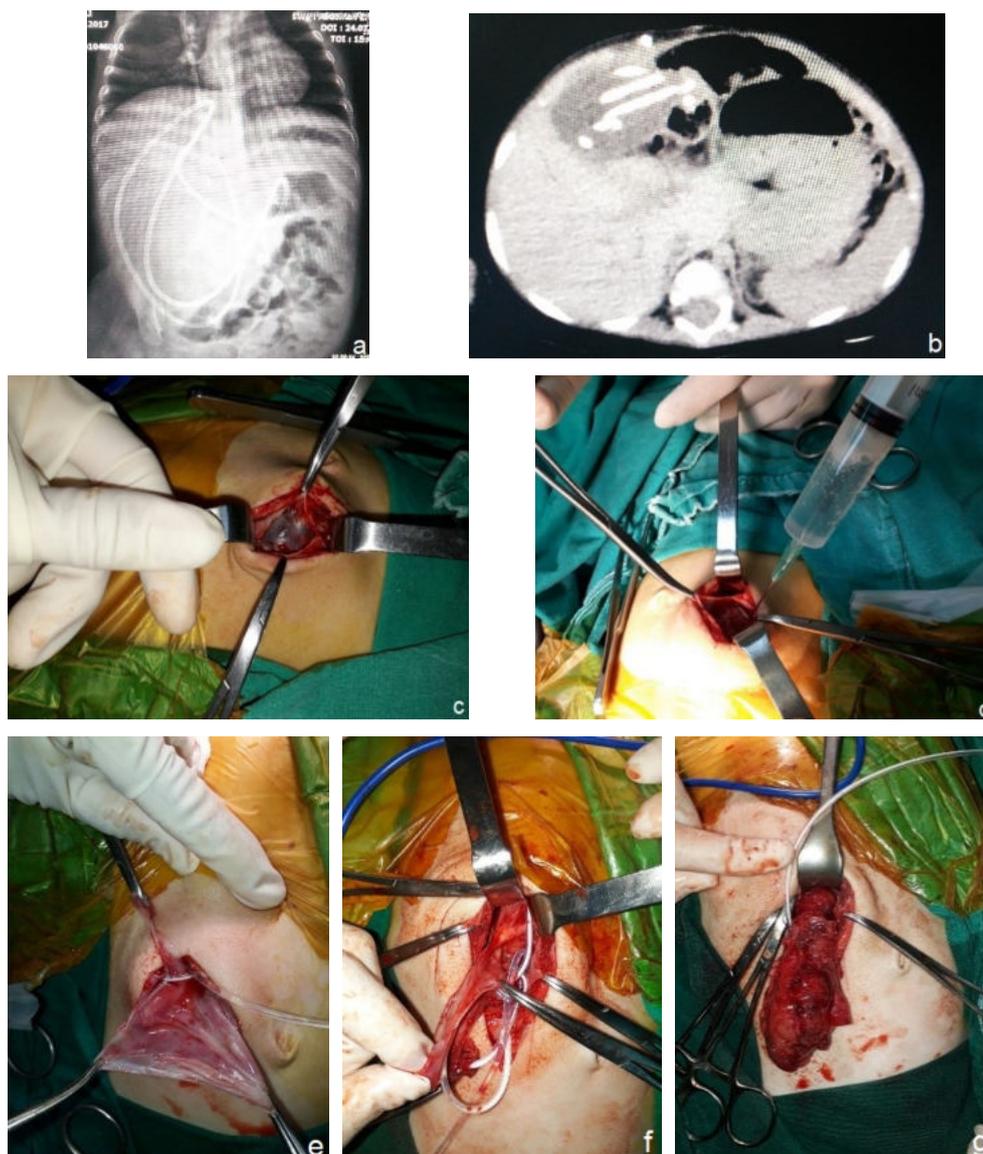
(a and b) The VP shunt catheter was showed on X ray and CT sagittal image, (c) Laparotomy performed by median insicision and large pseudocyst seen, (d) cyst aspiration and (e, f, and g) cyst excision and adhesiolysis performed.
